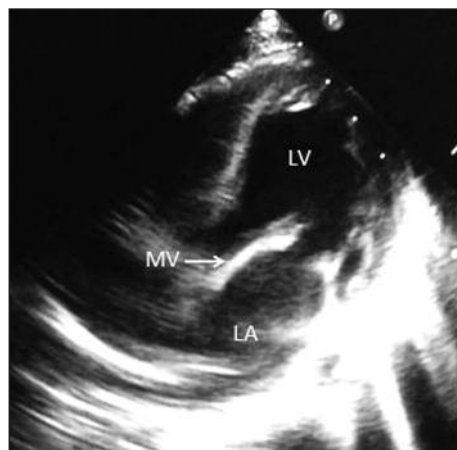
Arrow shows thickened mitral valve in echocardiographic examination.
